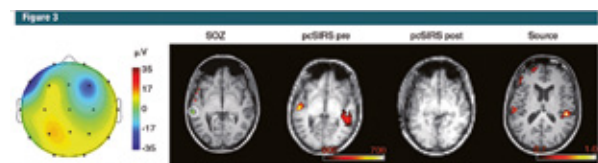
Images show exemplary results in patient with left temporal lobe epilepsy (patient 2). Far left image shows scalp voltage map of IEDs with maximum top activity in anterior frontal-temporal regions (blue). Second image shows location of intracranial electrodes. Circled green electrode recorded cortical epileptiform signals during seizure initiation and marks location of SOZ. Third and fourth images show distribution of PC-SIRS effects before and after resolution after surgery (green). Final image shows map of source reconstruction based on IED map of scalp voltage map (that image). Overlays for source to IED images were made on transverse planes of T1 weighted anatomical MR imaging. All images are in neurologic convention (left in image corresponds to left hemisphere).
